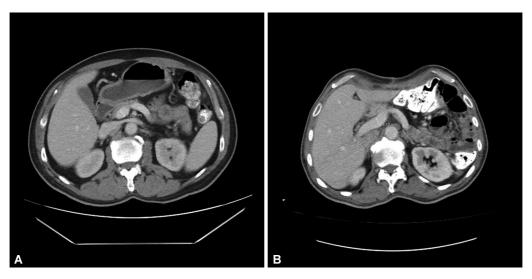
A 63-year-old male patient; CT images in the axial plane showing (A) preoperative MPV diameter 12.02 mm and (B) postoperative sixth month MPV diameter 16.10 mm. CT, computed tomography; MPV, main portal vein.
